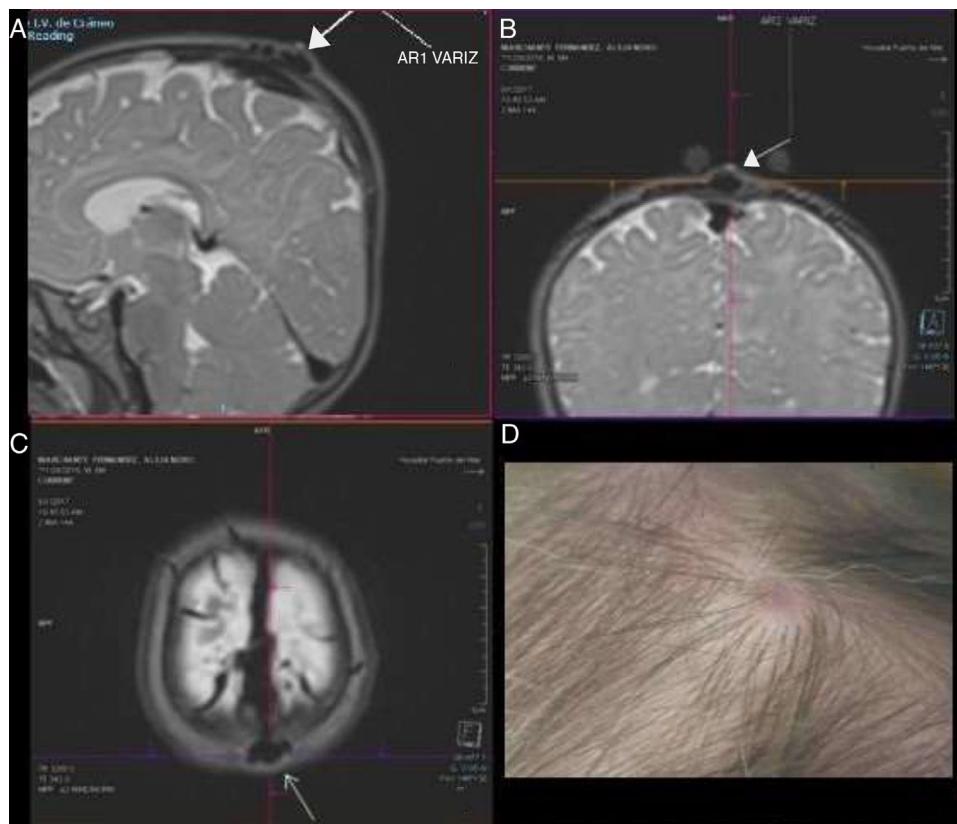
(A) Sagittal T2-weighted MRI sequence. The white arrow (signal voids) points to the varicose vein draining to the sagittal sinus. (B) Coronal slice at the level of the varicose vein (white arrow). Protrusion is observed at the surface. (C) Axial sequence showing the lesion at the midline. (D) External appearance of the *Sinus pericranii*. A macule is visible on the scalp; its size fluctuated during examination.
